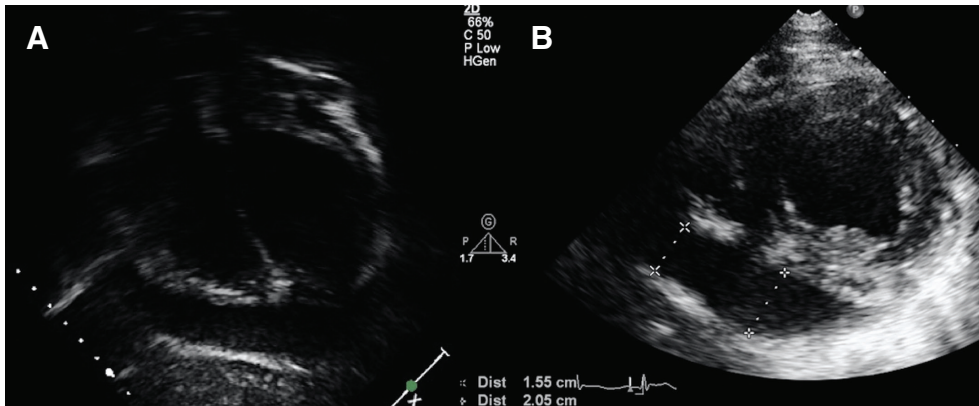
Echocardiography image on admission.
